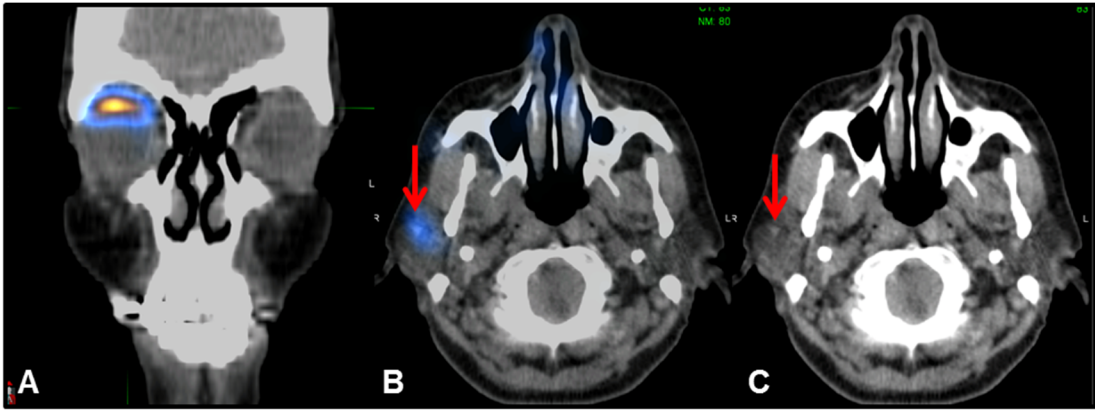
Tc-99m filtered sulfur colloid SPECT/CT (case #2). A: fused coronal image demonstrates successful radiotracer injection to the right eye subconjunctival region by ophthalmologist. B: fused axial image; and C, axial low-dose CT image. A tiny right parotid gland fossa sentinel lymph node was identified (red arrows in B & C). It was negative for metastasis on biopsy.
